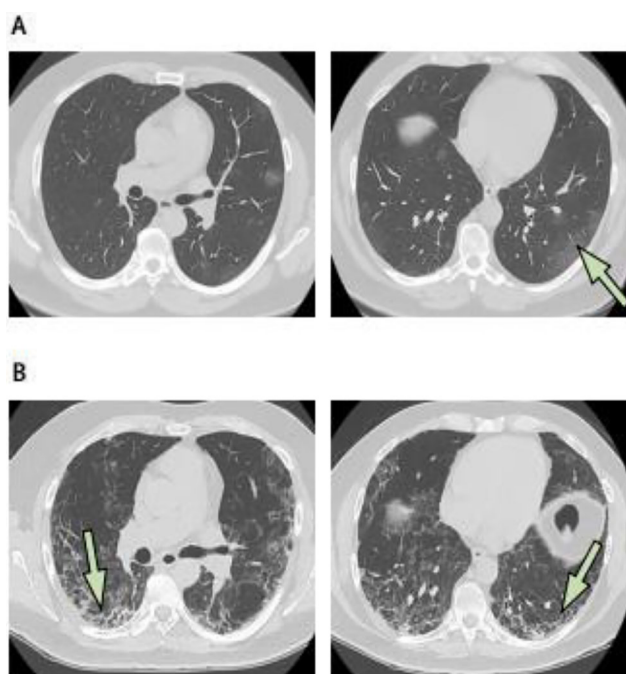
a In the early stages of the disease, soft ground-glass opacities were detected in the area indicated by the arrow in the left lung. b Pulmonary damage progressed rapidly in CT scan performed 3 weeks later and fibrosis occurred in the shown regions [34]
